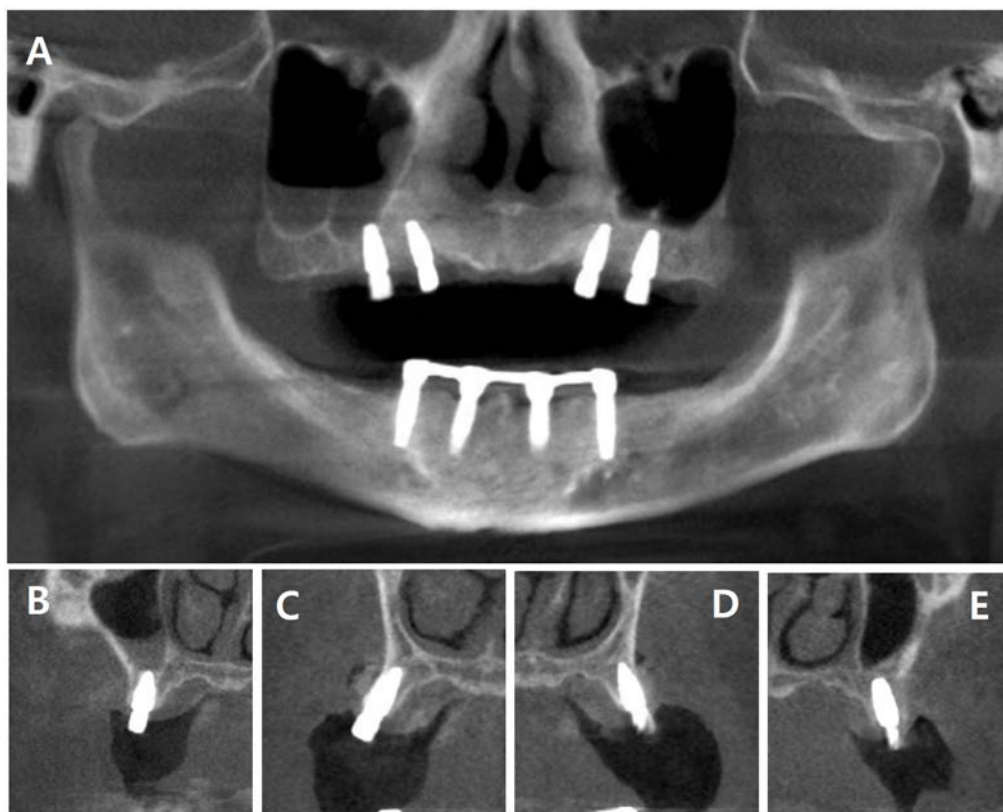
CBCT image after implant installation. (A) Panoramic view. (B) Paraxial view of #15 implant. (C) Paraxial view of #13 implant with lateral GBR. (D) Paraxial view of #23 implant with lateral GBR. (E) Paraxial view of #25 implant.
